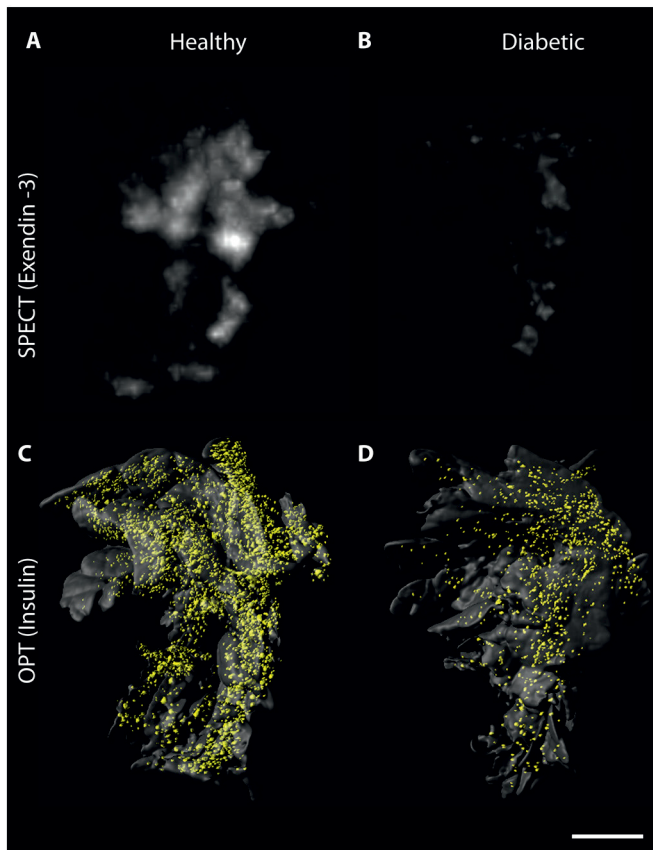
Multimodal imaging of pancreatic β -cells with SPECT and OPT.
